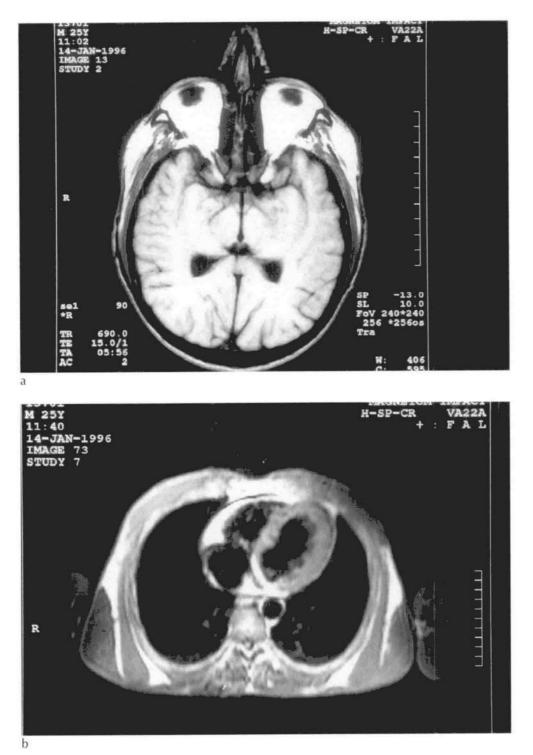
Axial T1-weighted MRI images of the a head, b thorax and c abdomen. Fat appears white. There is an absence of subcutaneous fat, whereas in other areas such as the orbits, mediastinum and intra-abdominal cavity, fat is clearly present.
